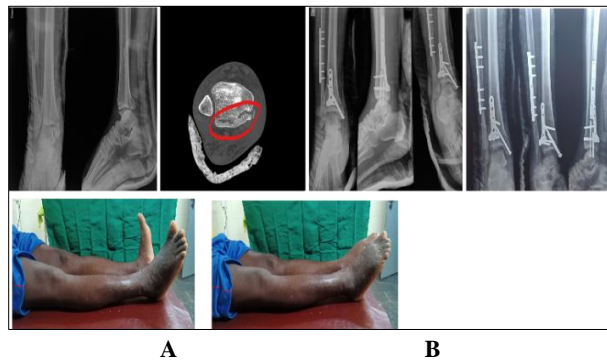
(A) Pre-operative radiograph of 37year old male, showing Denis weber type-C tri-malleolar fracture of right ankle. (B) and (C) Post-operative radiograph showing anatomic reduction and stable fixation using various implants.
